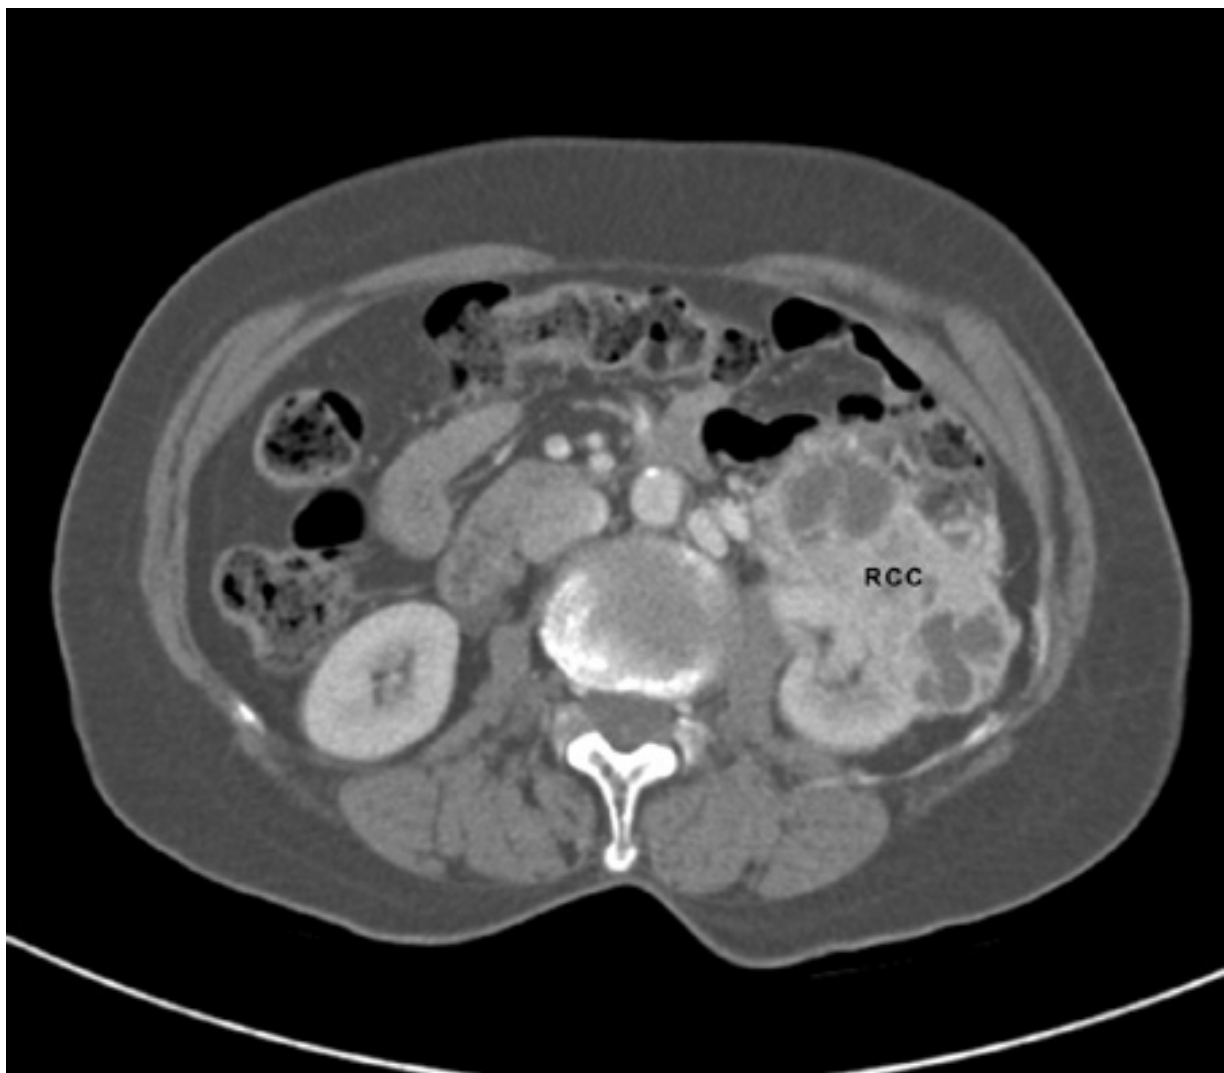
CT of renal cell carcinoma (RCC) of the left kidney
